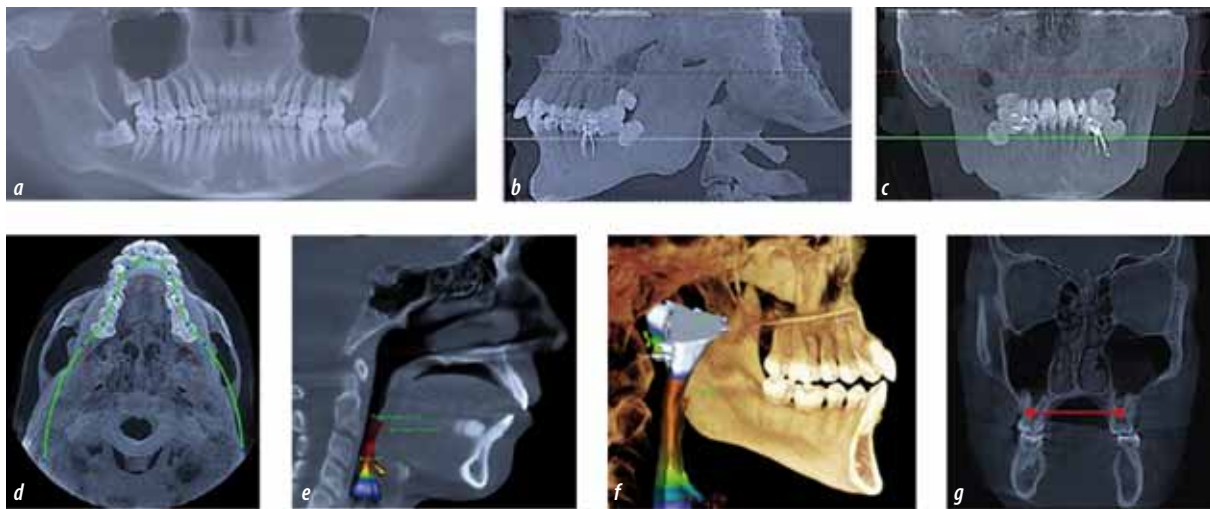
Cone-beam computed tomography; patient A., 16 y.o., with the upper jaw skeletal narrowing: a, b, c — panoramic reconstruction; d — axial projection; e, f — sagittal projection with the airways volume analysis; g — frontal projection with marks for YTI identification
